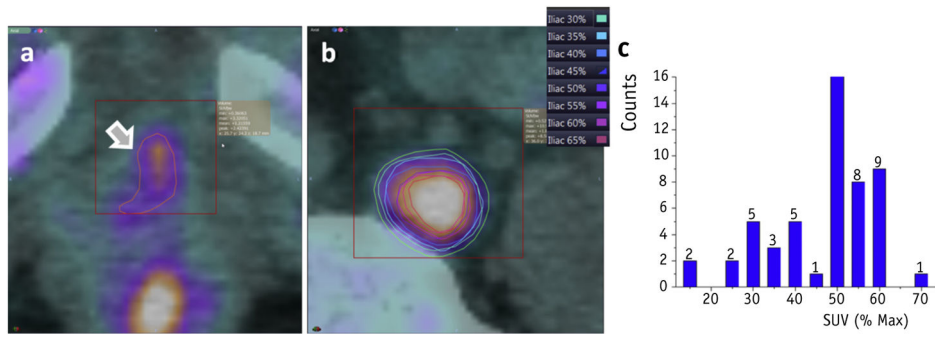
Lesion segmentation. The region of interest and segmentation of maximum standardized uptake value (SUV) with the region is shown for (a) a prostate bed lesion and (b) a lymph node lesion. (c) A histogram of threshold frequencies selected across all patients, with 50% of standardized uptake value (SUV)max being the most common value used for segmentation.
